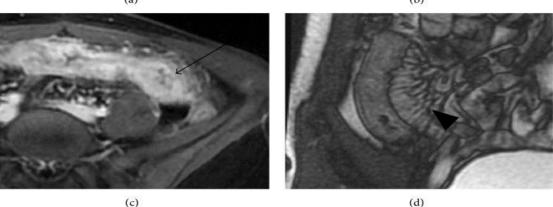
Signs of active CD as revealed by MR enterography. [(a) Coronal T2-weighted image showing thickening of wall (arrow), axial T1-weighted fat-suppressed postcontrast images that were collected in enteric (b) and delayed (c) phases showing early mucosal (b), arrowhead) with progressive transmural ((c), arrow) enhancement; coronal balanced steady-state free precession image (d) showing mesenteric hypervascularity (arrowhead) ⁽²⁰⁾.
